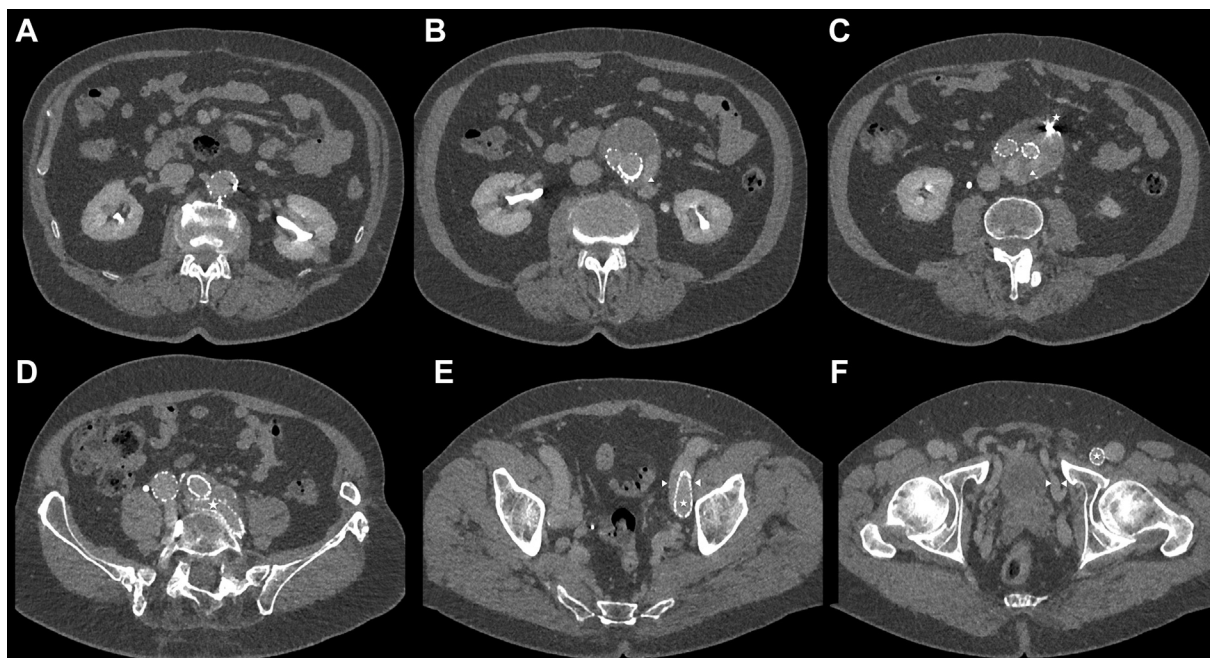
Follow-up axial contrast-enhanced computed tomography (CT) scans in the venous phase 14 months after surgery. A, Main body of the stent graft at the level of the right renal artery (*arrow*). B, Abdominal aortic aneurysm with the two stent graft legs, contrast enhancement in the sack of the aneurysm (*arrowhead*) indicating a type II endoleak. C, Abdominal aortic aneurysm with the two stent graft legs, contrast enhancement in the sack of the aneurysm (*arrowhead*) and coiled inferior mesenteric artery (*star*). D, Right and left common iliac arteries with stent grafts. Open left common iliac vein (*) with stents. E, Open left externa iliac vein and stents (*) at the level of the venous aneurysm. Arrowheads indicating the present diameter of the aneurysm. F, Open left common femoral vein with a stent (*). Persistent dilated pelvic veins (*arrowheads*).
